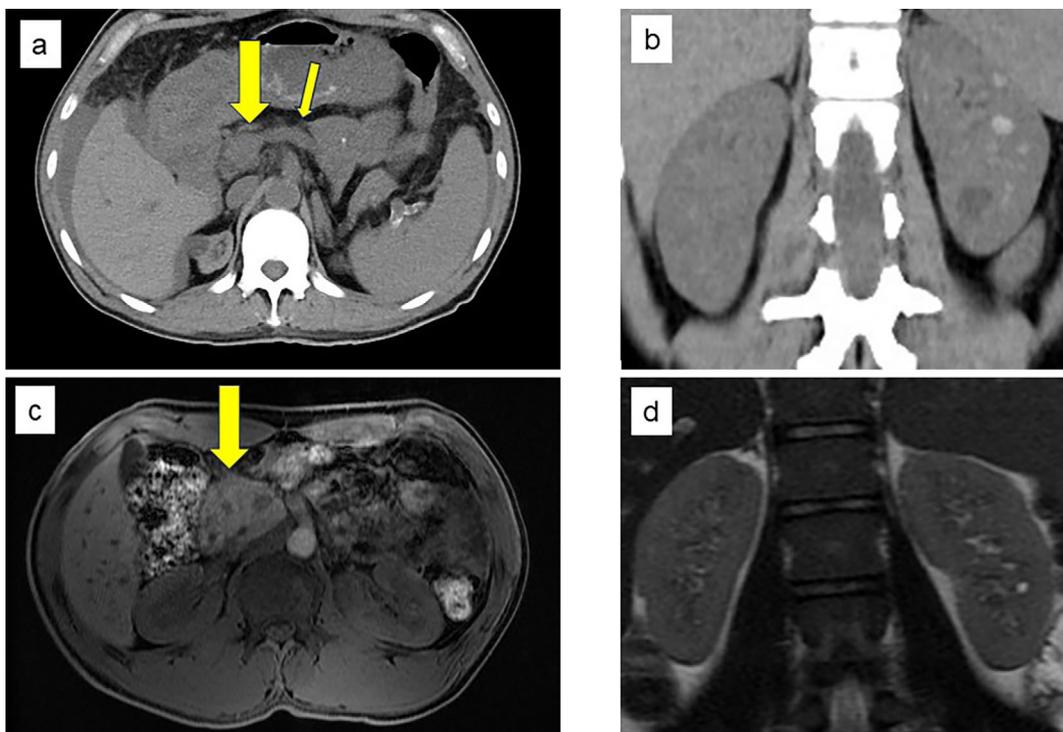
Computed tomography findings. a: Pancreatic head (large arrow) and hypoplasia of the pancreatic body or tail (small arrow) in patient II-2. b: Kidney cysts in patient III-1. Magnetic resonance imaging findings. c: Pancreatic head (arrow) and agenesis of the pancreatic tail in patient III-2 (LAVA-Flex sequence). d: Kidney cysts in patient III-2 (T2-weighted SSFSE sequence).
